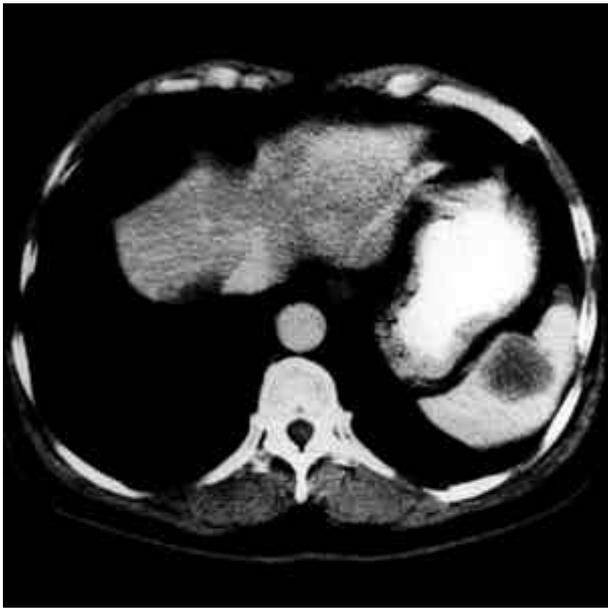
CT demonstrates a low-attenuation area in the superior splenic area (right lower corner).
